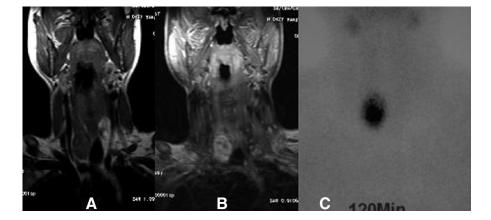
A, B, The parathyroid tumor showed a high signal on T2 and enhanced images on MRI compared with surrounding tissues. C, Tc-99m MIBI scintigraphy of the parathyroid showed increased uptake.
